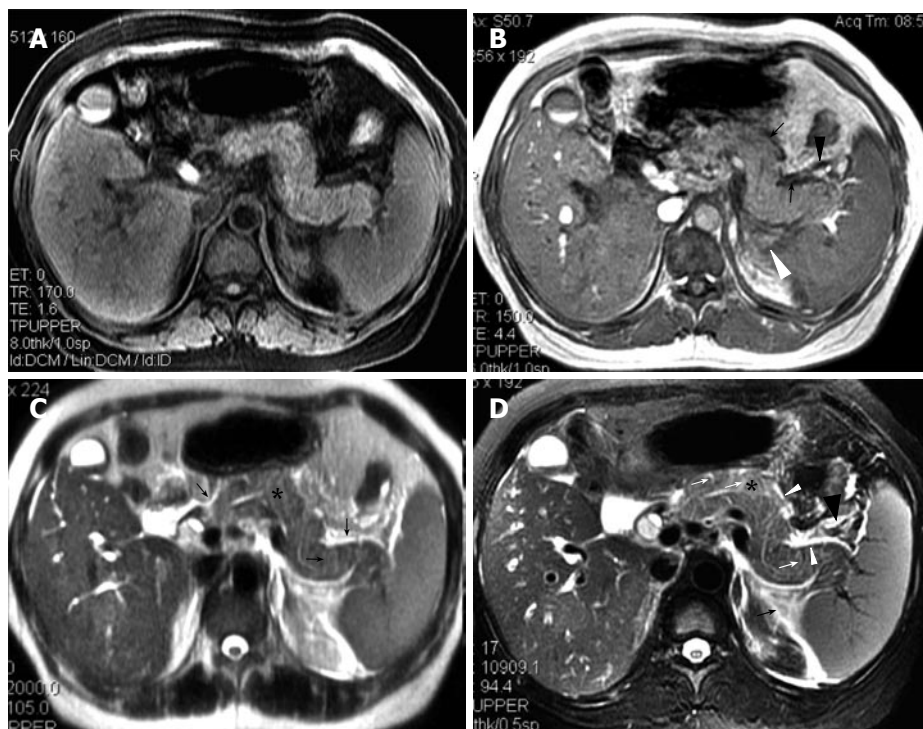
A 42-year-old woman with interstitial edematous pancreatitis. A: SPGR fat-suppressed T1-weighted (TR/TE = 170/1.6 ms) image shows pancreatic signal intensity comparable to that of liver; B: GRE in-phase (TR/TE = 150/4.4 ms) image shows pancreatic fascial plane (arrows) and peripancreatic fat stranding (arrow heads); C: SSFSE T2-weighted (TE = 90 ms) image shows increased pancreatic signal intensity (asterisk). Stranding in the pancreatic fascial plane (large arrow) and peripancreatic fat and thickened pancreatic lobular septum (small arrow) can also be seen; D: R-T T2-weighted (TR/TE = 11 800/93 ms) image shows above findings much better (Asterisk indicates pancreatic parenchyma, white arrows indicate thickened pancreatic lobular septum, white arrow head indicates pancreatic fascial plane, and black arrow and arrow head indicate fat stranding).
